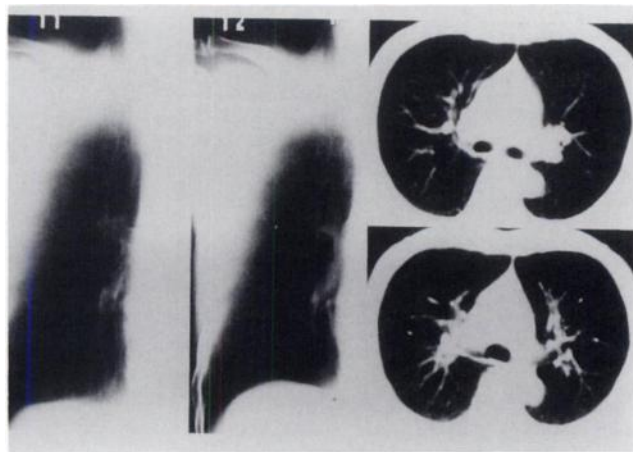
Tomograms of computed radiography of the right chest showing no abnormal findings. Computed tomograms reveal no abnormal mass other than the irregularity of the right main bronchus.
